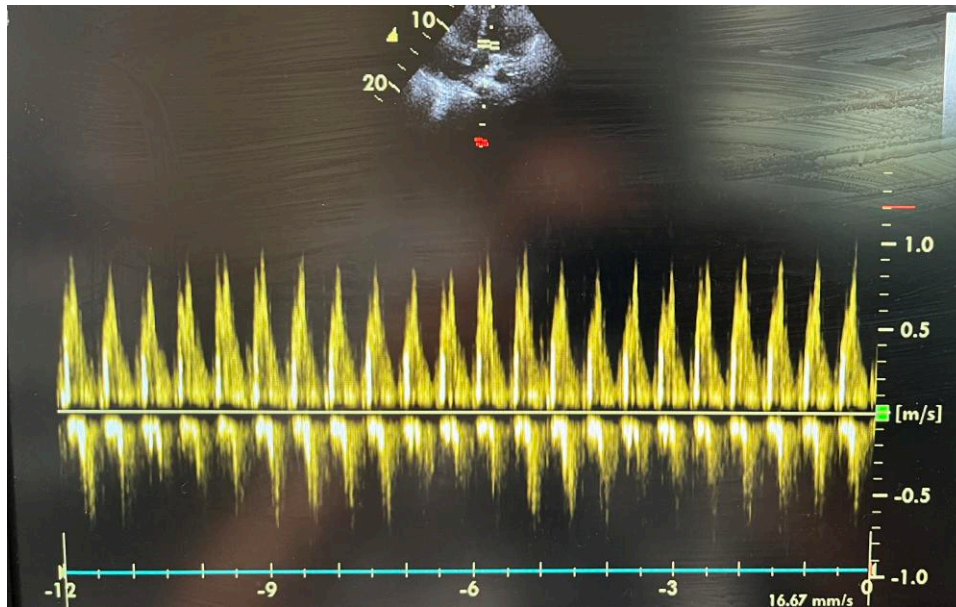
Echocardiography shows 20% variations in transmitral inflow.
